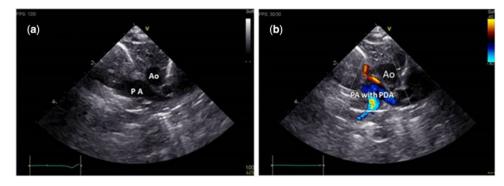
Echocardiogram. (*a*) Transposition and (*b*) Doppler study. Ao=aorta; PA=pulmonary artery; PDA=patent ductus arteriosus.
